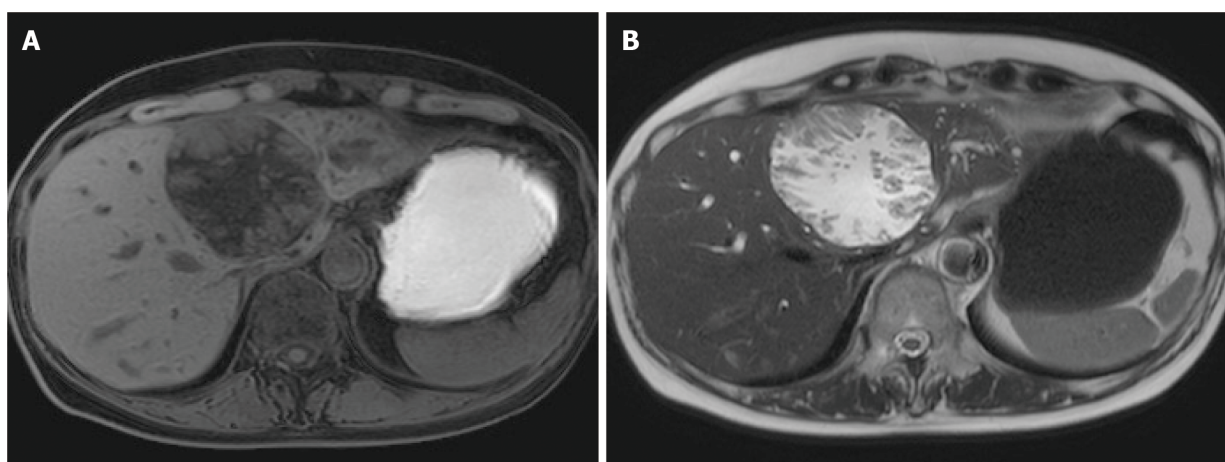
Magnetic resonance imaging. A: T1-weighted image; and B: T2-weighted image papillary solid lesion protuberating from cystic wall is noted and the cystic component showed the same signals as water. Transportation between the cyst and the root of left hepatic duct is noted.
